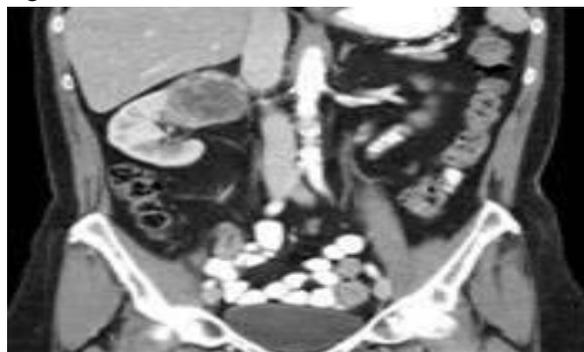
Sagittal section of CT-scan showing right renal mass.
